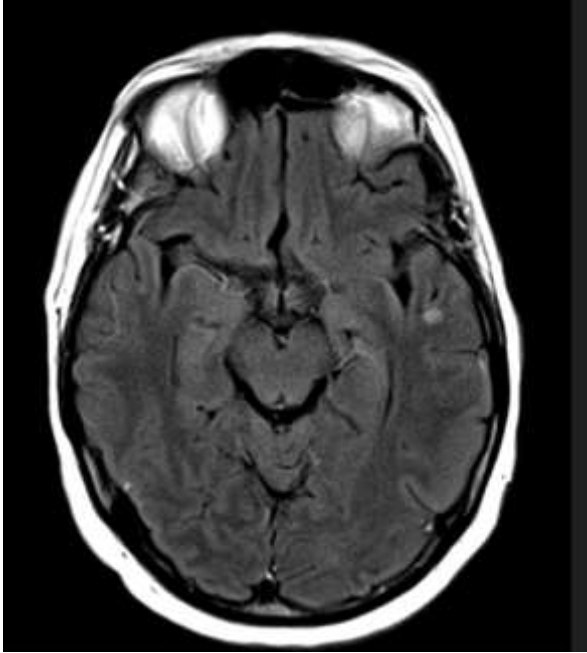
Focal hyperintense lesion in left temporal lobe on axial FLAIR sequence
